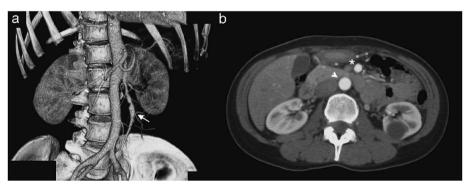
Preoperative computed tomographic angiography shows a superior mesenteric artery (SMA) aneurysm. (A) The SMA is dilated into a spindle form from the middle (arrow).
